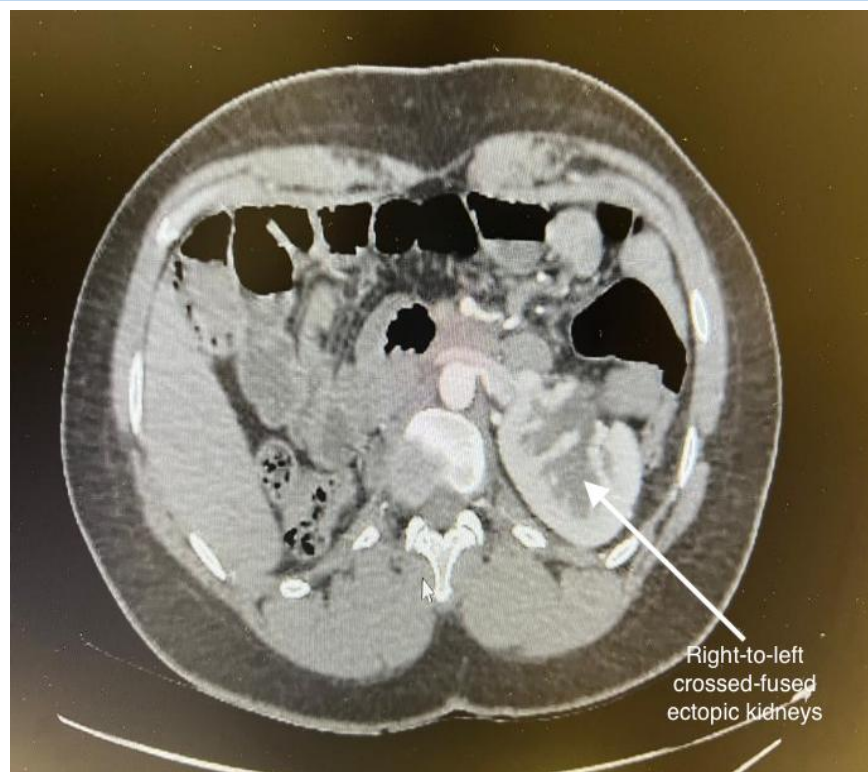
Contrast-enhanced abdominal CT scan showing a right-to-left positioning of the crossed ectopic kidneys with an empty right renal fossa.
